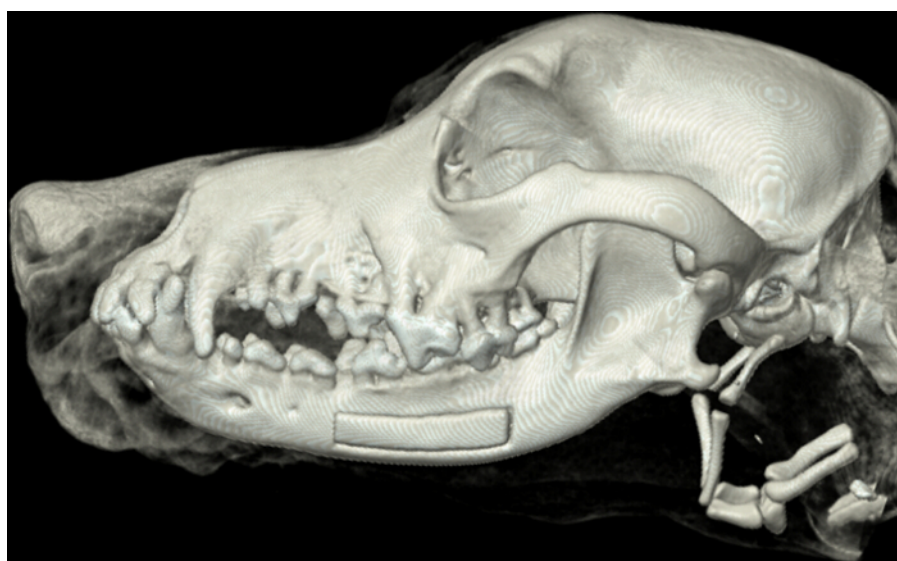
Computed tomography imaging of the facial bone after left inferior alveolar nerve reconstruction. The image shows that the mandibular bone plate is in the proper position. [Please click here to view a larger version of this figure.](#)
